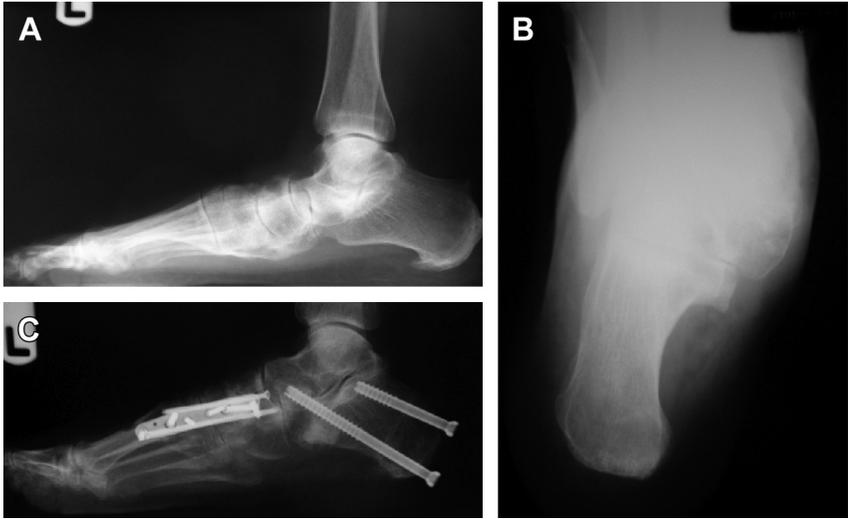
(A) Preoperative lateral projection showing malalignment of midfoot and hindfoot causing abnormal forces along the posterior tibial dysfunction. (B) Preoperative view of hindfoot alignment showing a calcaneal valgus, resulting in abnormal forces that lead to a posterior tibial tendon dysfunction. (C) Postoperative lateral radiograph showing the foot of a patient who underwent an endoscopic gastrocnemius recession, a percutaneous calcaneal displacement osteotomy, an Evans calcaneal osteotomy, and a midfoot fusion. Note the realignment of the midfoot and hindfoot, therefore decreasing the stress to the posterior tibial tendon. Surgery was not performed on the posterior tibial tendon, and the biomechanically realigned foot provides adequate support to the posterior tibial tendon without the need of a flexor digitorum longus transfer.
